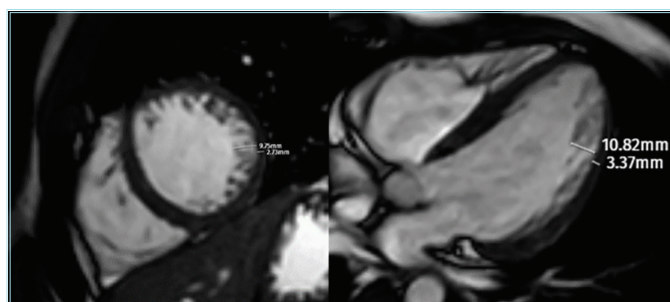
In cardiac magnetic resonance imaging images with white blood CINE imaging, an increased non-compacted-to-compacted ratio was observed in the left ventricular free wall, in the (right) short-axis and (left) long-axis views
